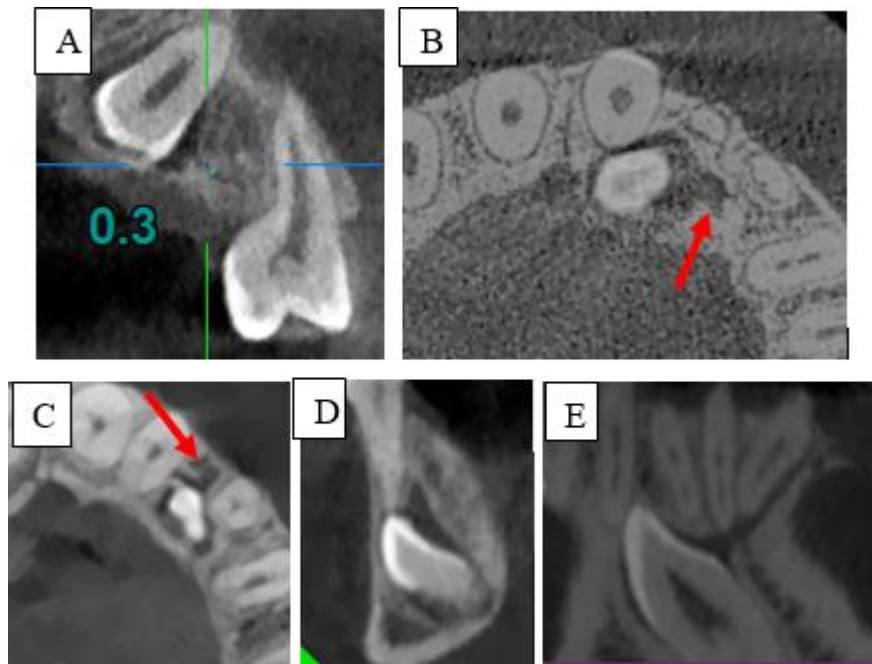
CBCT views show alteration in shape of GC: A: Thinning of GC (diameter <1 mm); B: Deformation; C: Folding; D: Obliteration; E: Change in direction.
